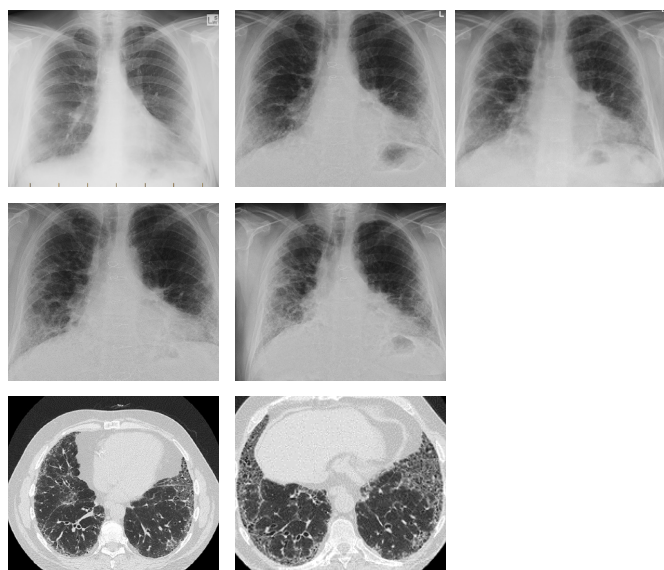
a. Chest X-Ray and chest CT Scans for patient A, showing progressive changes in the interstitial opacity
